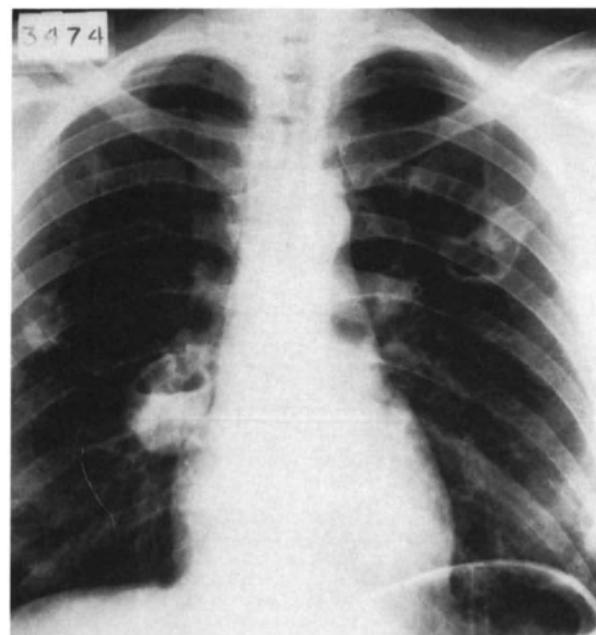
Chest radiograph of a patient with tricuspid valve endocarditis causing multiple septic pulmonary infarcts which developed into abscesses.
